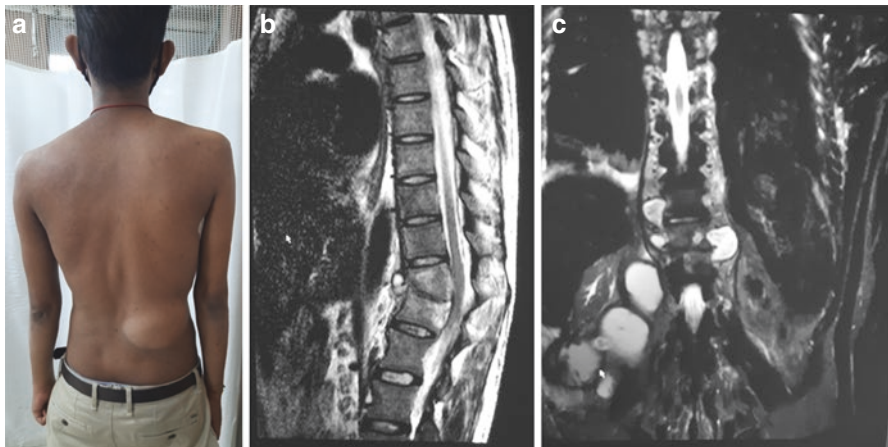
(a) CKD patient presenting with cold abscess in right loin with intact neurology. (b) T2 sagittal MRI showing T11-T12 spondylodiskitis. (c) T2 coronal MRI, large inflammatory mass in right paraspinal region extending till dermis
